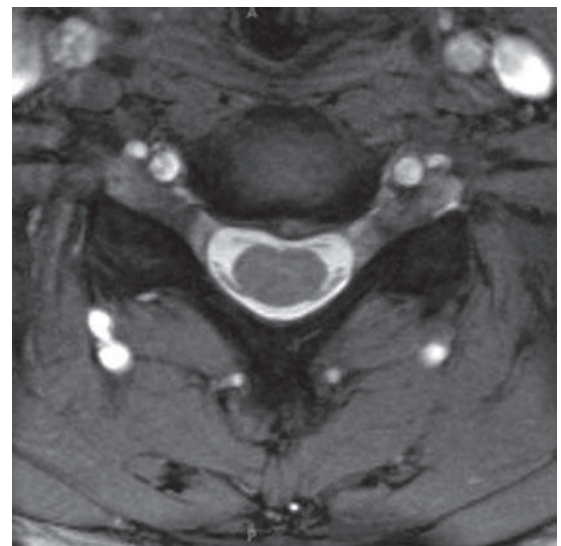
These axial (a) 1.5-T and (b) 3.0-T T2-weighted gradient-echo images of the cervical spine. The higher resolution image enables the identification of a small intraspinal lesion with surrounding edema, likely inflammatory in nature. (c) Sagittal and (d) axial 3.0-T T2-weighted TSE images of the lumbar spine show neural compressive pathology (a left L1-L2 disc extrusion with proximal migration of the fragment behind the L1 vertebral body) in high resolution. (a and b): From Runge VM. Cervical-cord (part 2). In: Runge VM, Nitz WR, Schmeets SH, Shoenberg SO (Eds). Clinical 3T Magnetic Resonance. New York, NY: Thieme; 2007:114–115. Reprinted by permission.)
